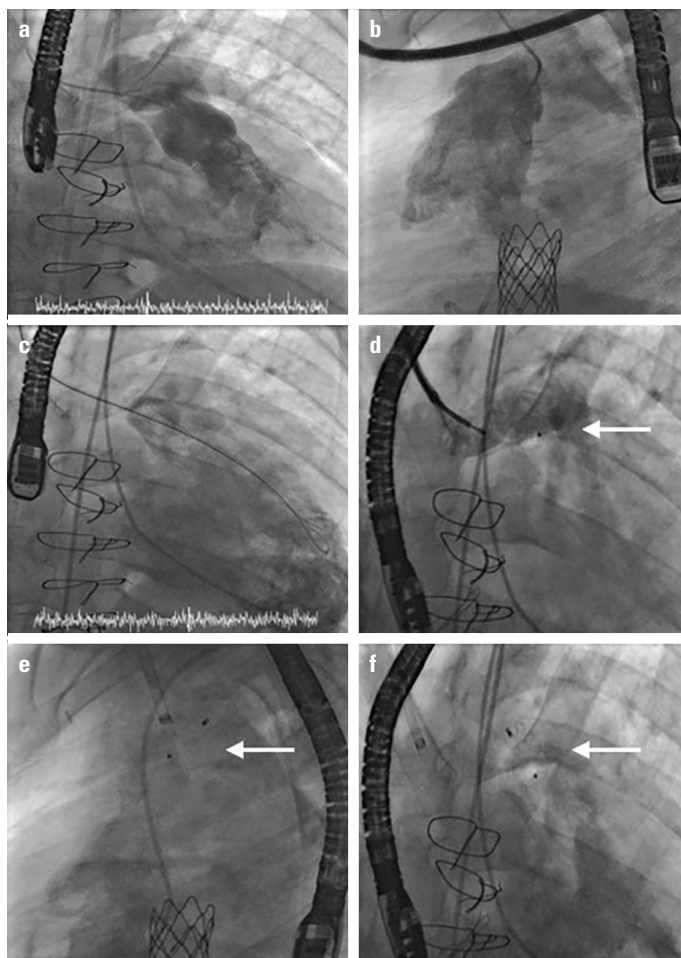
(a) The ventriculopulmonary shunt on posteroanterior projection. (b) The ventriculopulmonary shunt on lateral projection. (c) Balloon sizing of the ventriculopulmonary connection with simultaneous ventriculogram and transoesophageal echocardiogram. (d) Pre-deployment angiogram of the left pulmonary artery. (e) Post deployment angiogram on lateral projection with ventriculogram. (f) Post deployment angiogram on posteroanterior projection with ventriculogram
